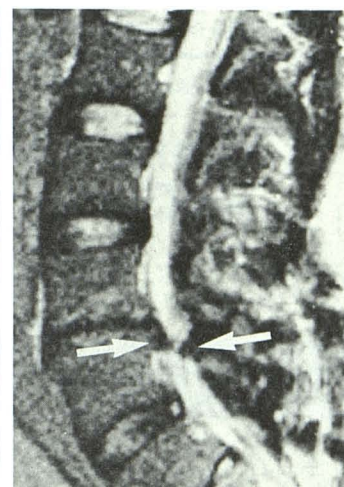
Postlaminectomy scar in 35-year-old man who underwent right L4–L5 discectomy 5 years earlier. Sagittal T2-weighted image demonstrates irregular indentation of hyperintense thecal sac at L4–L5 level both anteriorly and posteriorly by a hypointense mass (arrows). At surgery, “considerable scar” was encountered surrounding the sac, but no recurrent disk herniation was identified.
